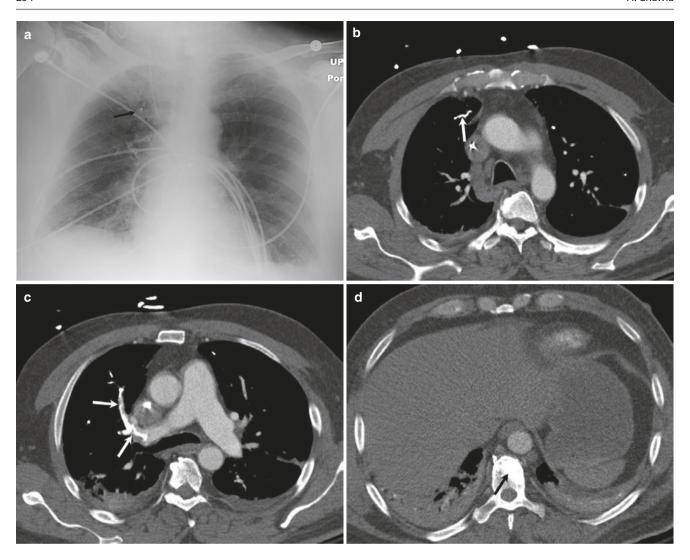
A 60-year-old man with shortness of breath 2 days after elective kyphoplasty of T9 and T10 vertebra. (a) Chest radiograph shows faint calcific densities (arrow) in the right upper zone. (b, c)
